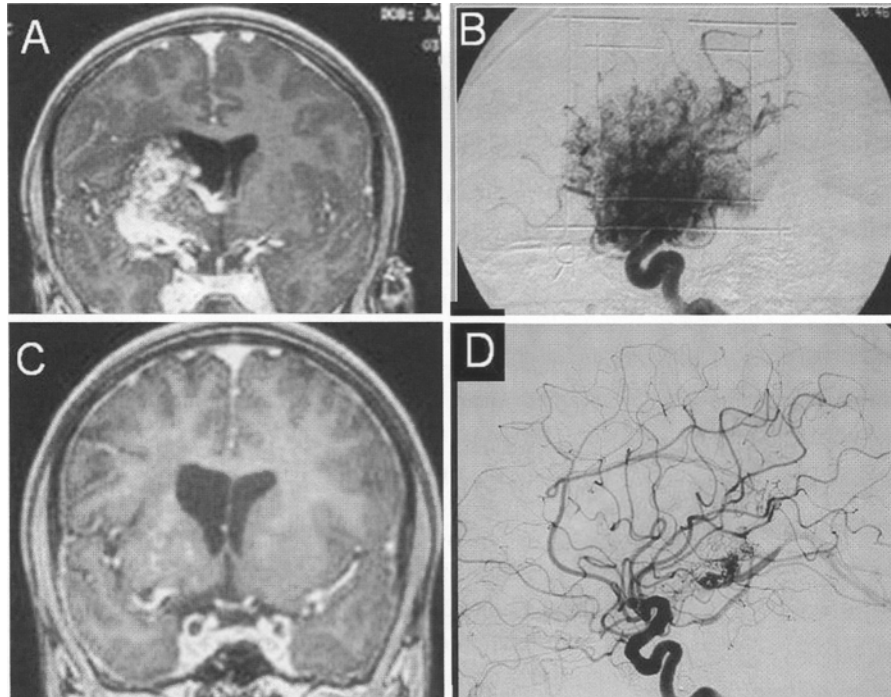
(A) T1 Magnetic resonance image with gadolinium enhancement showing the giant basal ganglia AVM before stereotactic radiotherapy. (B) Lateral cerebral angiogram showing the lesion at the time of the treatment (6Gy in 5 consecutive fractions). (C and D) Show the 4 year follow up, time of the radiosurgery of 15Gy
